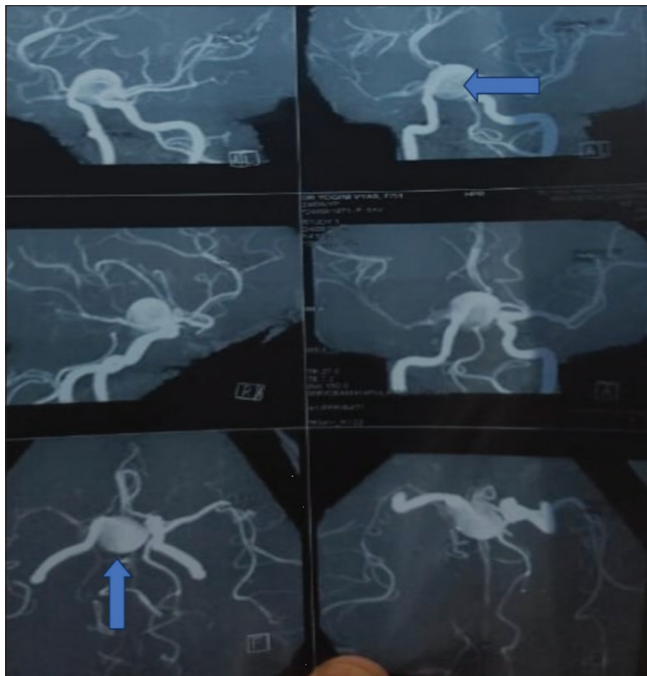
Magnetic resonance imaging brain with angiography showing the saccular aneurysm (blue arrow) at the junction of middle carotid artery and internal carotid artery.
